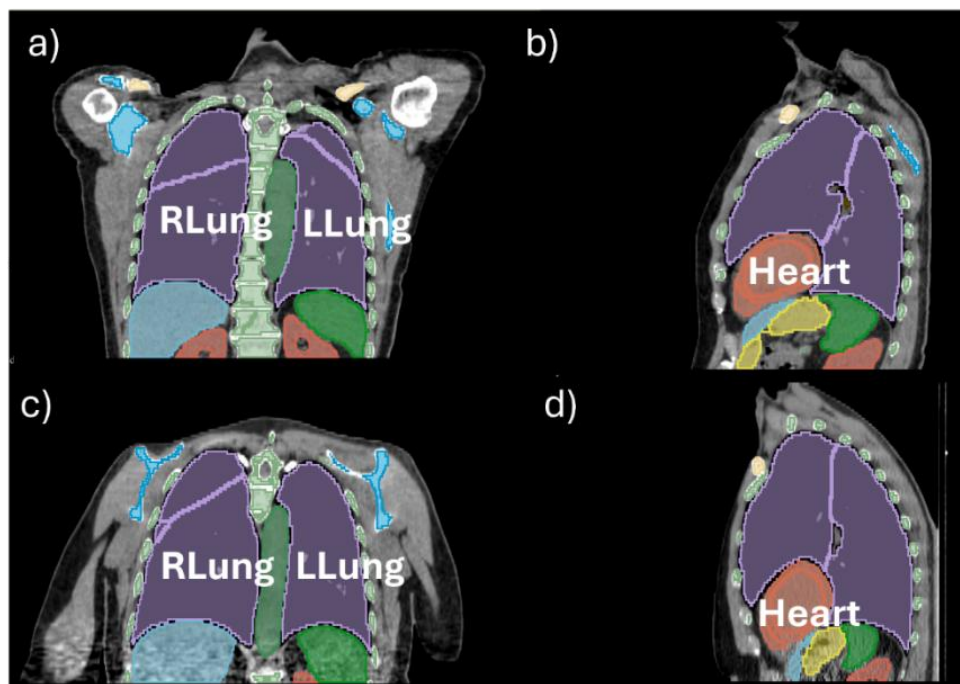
Patient P2 TotalSegmentator output on supine (a,b) and upright (c,d) reference CT, in coronal (a,c) and sagittal (b,d) view. RLung=Right Lung, LLung=Left Lung.
